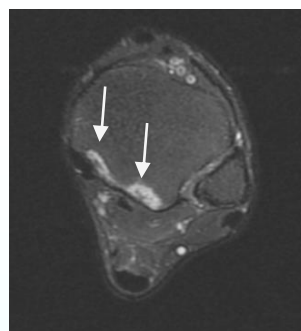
A 29-year-old man referred to MRI examination for recurrent left ankle sprain. It showed two rims (white arrows) of abnormal bony edema at the posterior aspects of the tibia. Patient received 6 sessions of USG diathermy in the past 4 weeks before MRI examination
